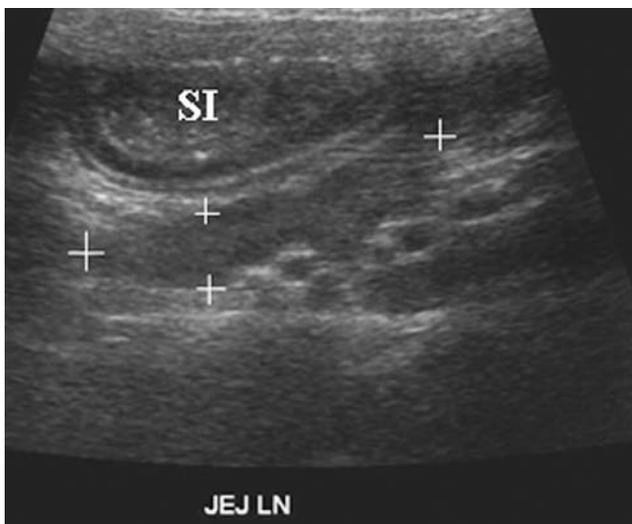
Longitudinal ultrasound image of a normal canine jejunal lymph node. SI = small intestinal loop.
